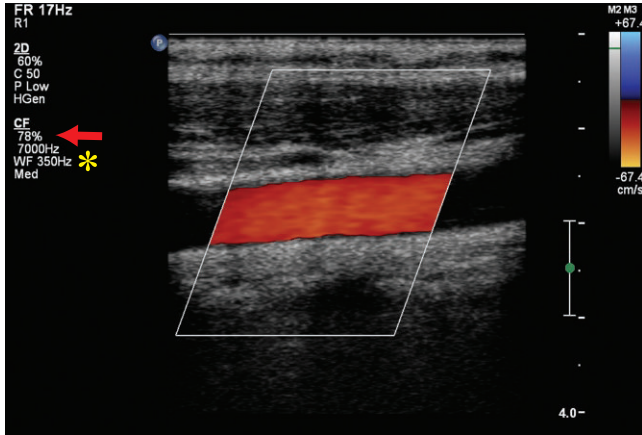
Color Doppler shows the color in the artery outlines the wall of the vessel. Note the color gain (arrow) and the wall filter (*).
